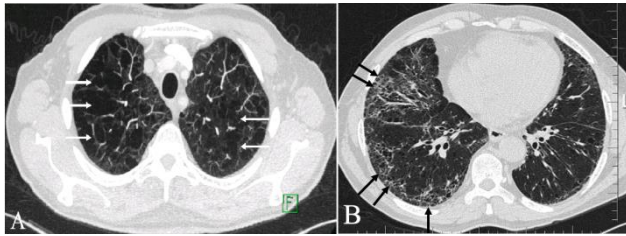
A 58-year-old male heavy-smoker with a normal PFT. Axial contrast-enhanced thorax CT images show bilateral emphysema in upper lobes of the lungs (*white arrows, A*) and interlobular septal thickening dominantly in the right lung (*black arrows, B*).
